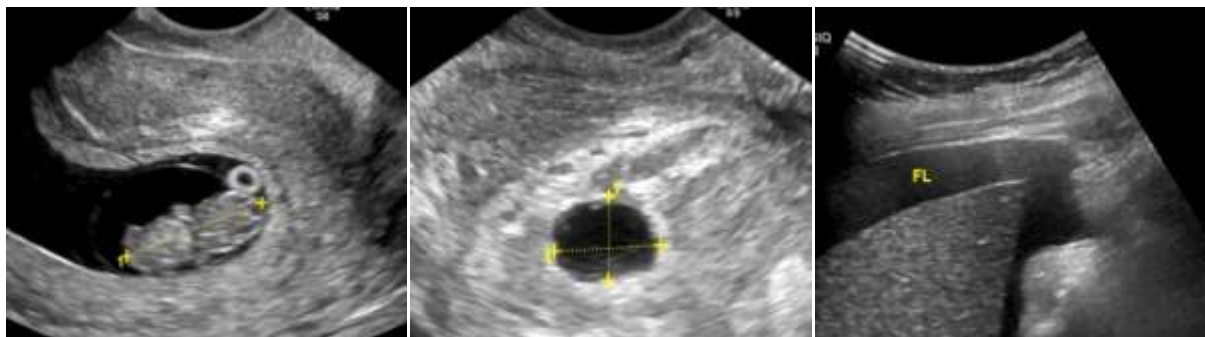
Ultrasound abdomen showing Fig 1 - an intrauterine pregnancy of 10 weeks. Fig 2 - intra tubal pregnancy (Left Adnexa) Fig 3 - free fluid in Morrison's pouch
